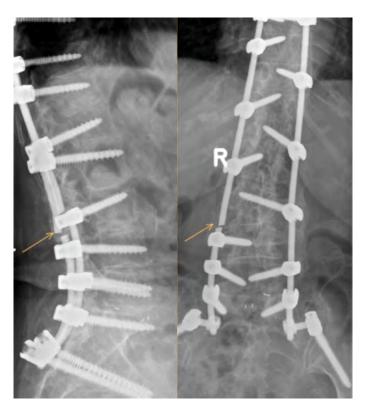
X-ray a.p and laterally in standing position shows a rod fracture as an indirect sign of pseudarthrosis
